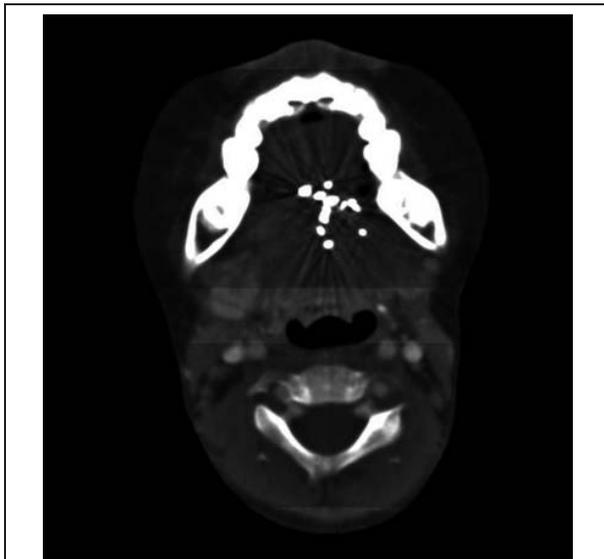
CT scans showing local response 32 months after iodine-125 (¹²⁵I) seed implantation.
